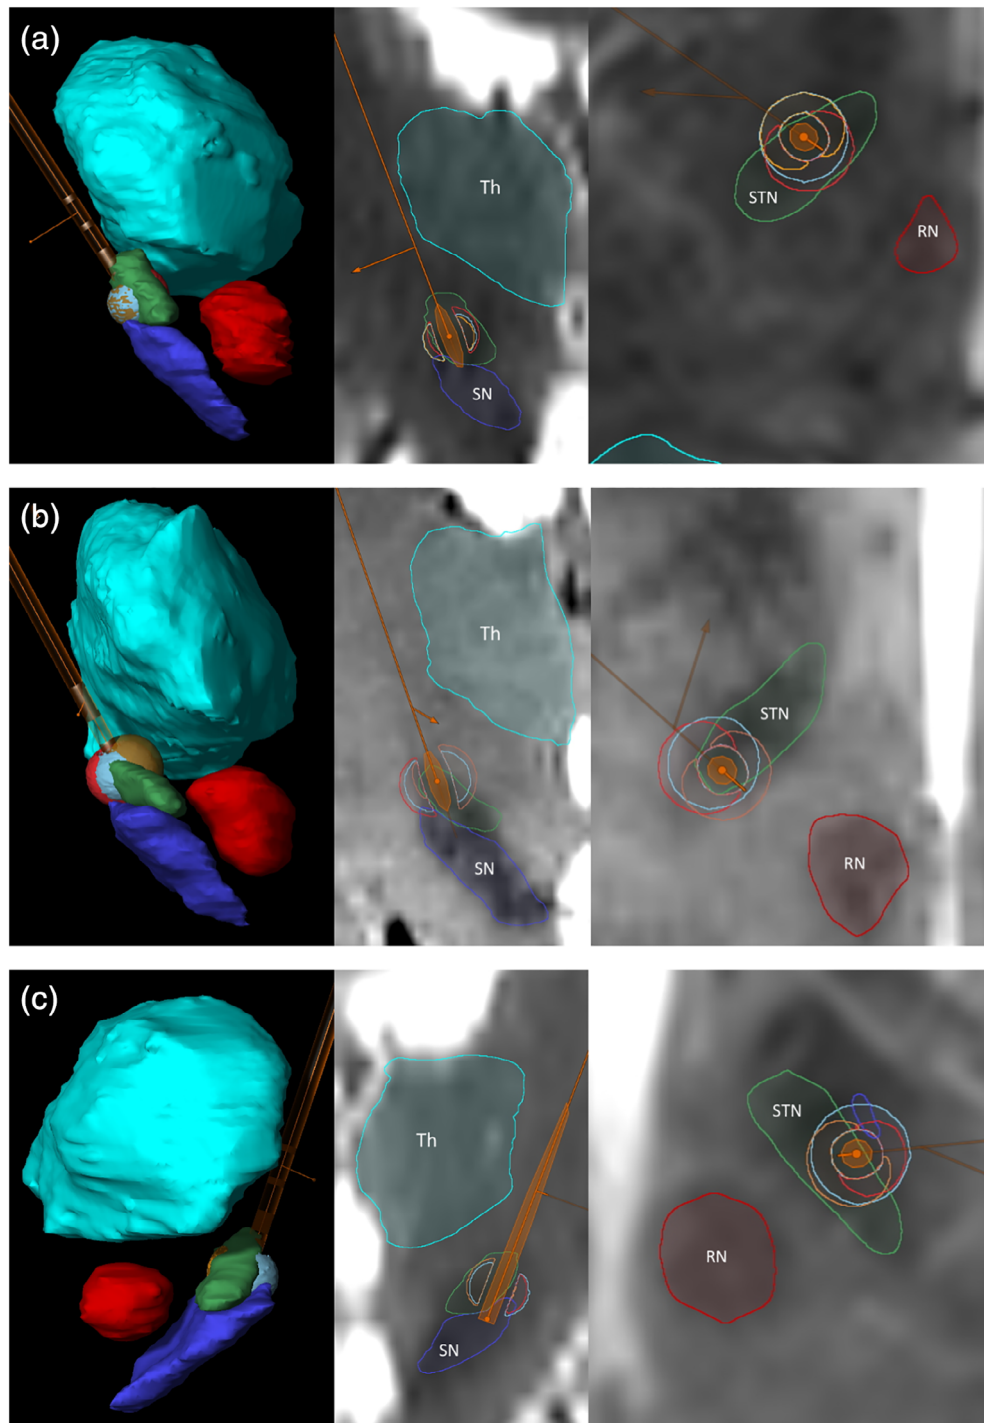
Representative VTA models in patients with (A) speech impairment (right STN), (B) dyskinesia (right STN), and (C) pyramidal adverse effects (left STN). 3D models are shown on the left; T₂-weighted MRI coronal view in the middle and axial view on the right for each patient. The baseline VTAs are indicated in light blue, optimized VTAs in yellow, and direction of segment with lowest side effect threshold in red. These images correspond to the clinical audio and video recordings included in the Supplementary Information. Nuclei: Th, thalamus (turquoise); STN, subthalamic nucleus (green); RN, red nucleus (red); SN, substantia nigra (indigo). [Color figure can be viewed at wileyonlinelibrary.com]
